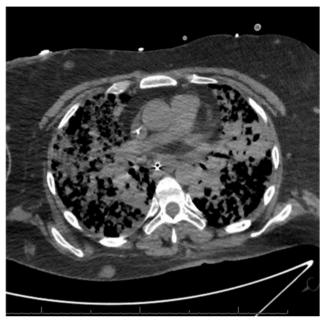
Figure (above): Chest x-ray and CT chest demonstrated pulmonary consolidation and subcutaneous soft tissue nodules in patient's chest and abdomen.
